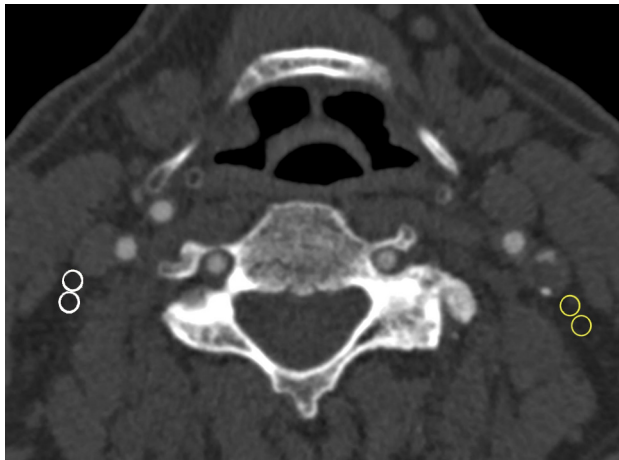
Axial CT image of a 71-year-old-man with left ischemic stroke. Two ROIs were positioned in the PCF surrounding a stenotic left internal carotid artery with a vulnerable plaque (yellow circles), and 2 ROIs were placed in the contralateral carotid artery in the same section (white circles) to measure perivascular fat attenuation. The PCF demonstrates an HU value of 58.3 and 61 in the left carotid artery and 75.2 and 78.5 in the right carotid artery, respectively.
